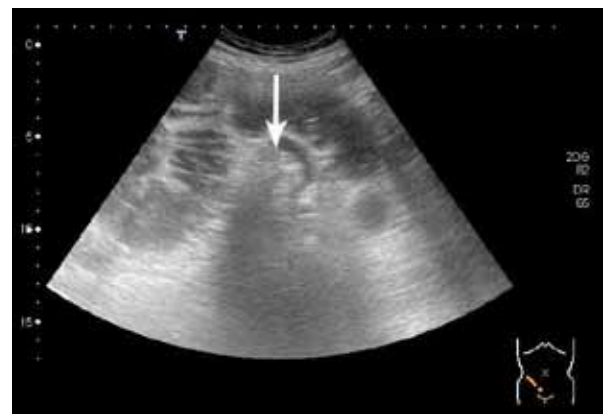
Abdominal ultrasound showing a hyperechoic mass about 2.8cm (arrow) with distended small bowel loop with keyboard sign.
